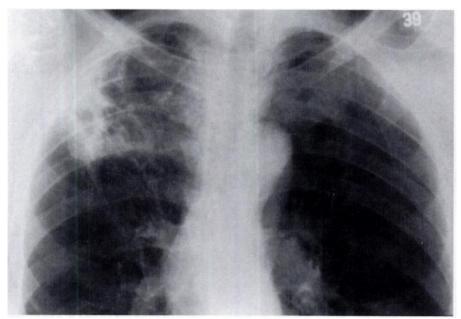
Classical form of disease associated with chronic obstructive pulmonary disease in an elderly man who developed chronic cough and constitutional symptoms. *M kansasii* was recovered from the sputum. Chest radiograph shows characteristic fibroproductive changes in the right lung apex. Chronic obstructive pulmonary disease is the most common predisposing condition in classical NTMB infection.
